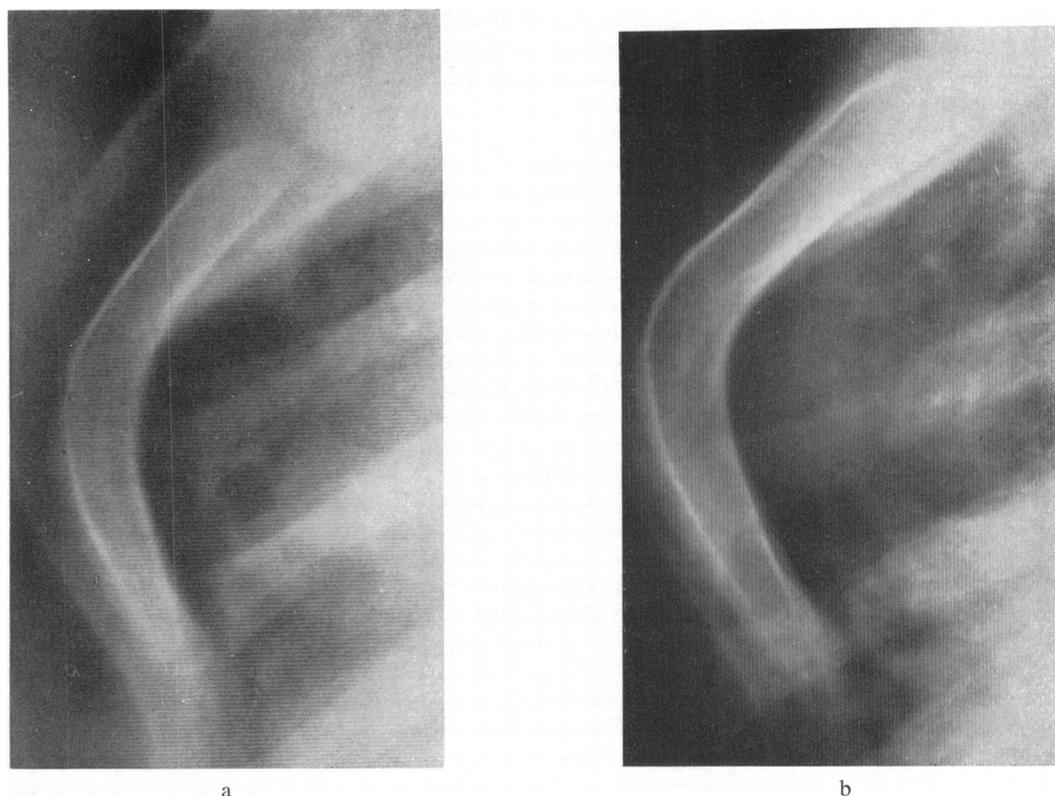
X-ray of sternum in Case 1, showing fusion of the manubrium and body of the sternum with forward curvature (a) at 2 years of age and (b) at 5 years.
